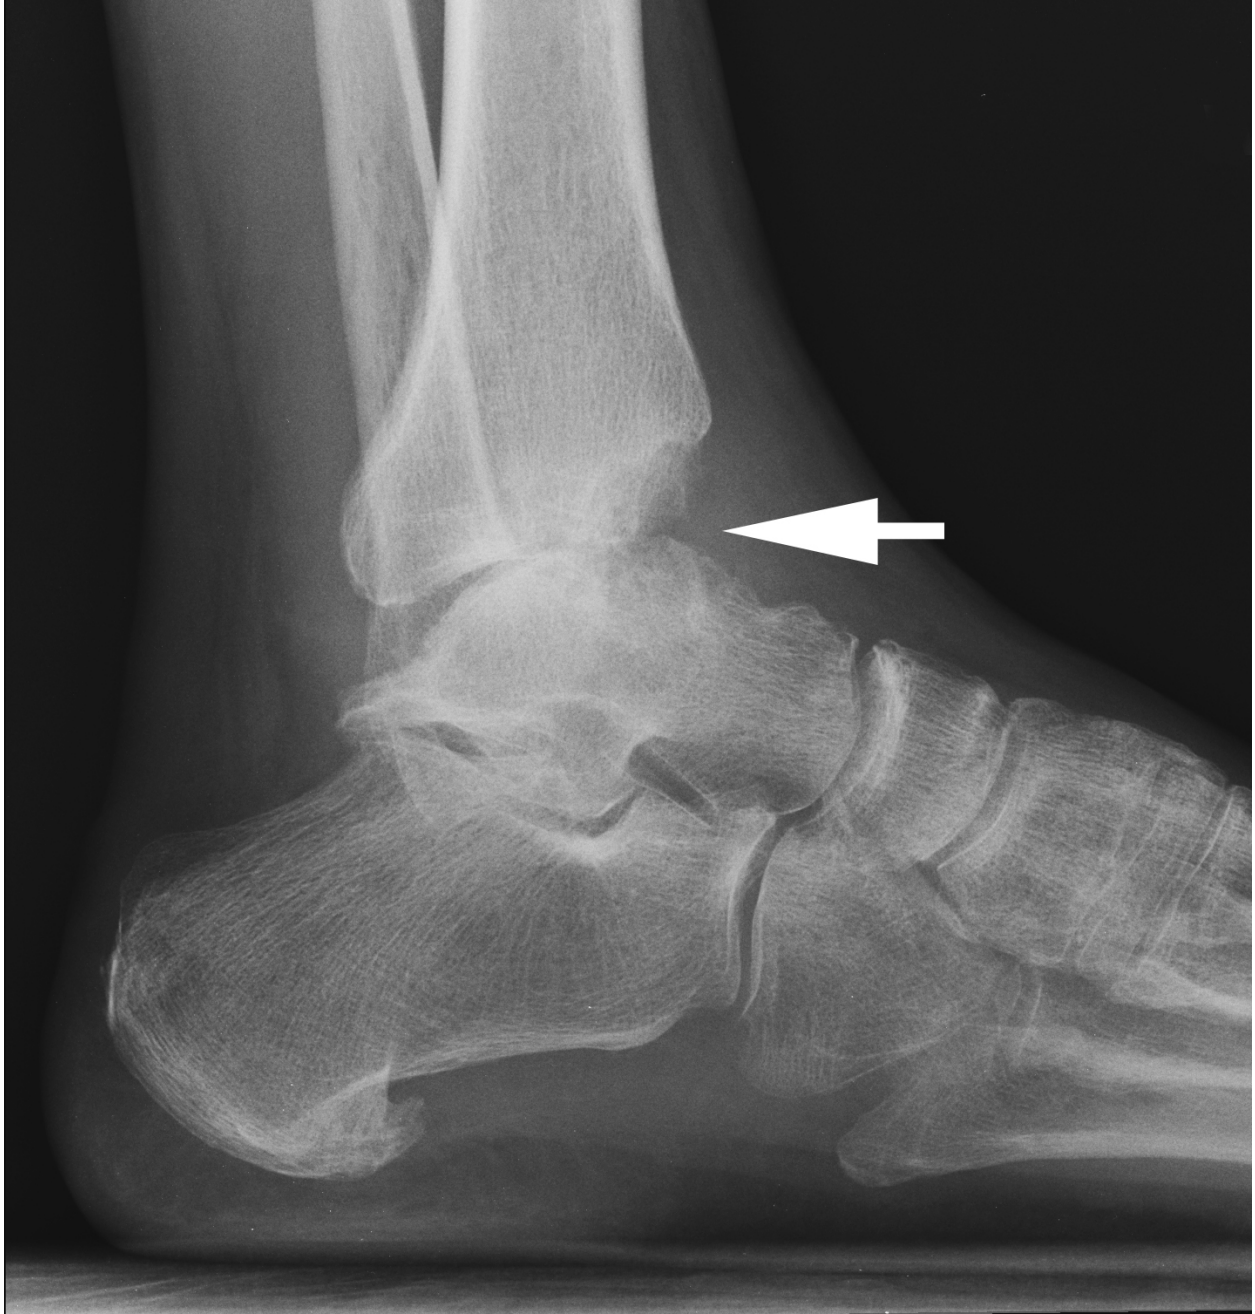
(a). Hemophilia. Lateral radiograph of the left ankle shows erosions on the anterior aspect of the distal tibia and dome of the talus (arrow) with a joint effusion.
